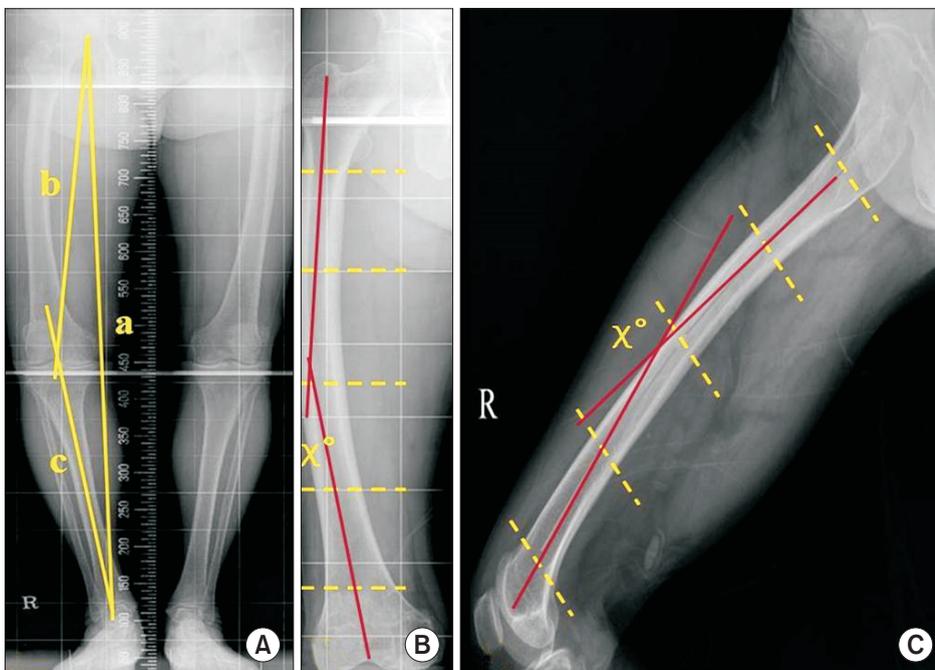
(A) Standing anteroposterior radiograph of the entire lower limbs. a: mechanical axis of the lower limb, b and c: amount of varus deformity. (B) Lateral bowing of the femur. (C) Anterior bowing of the femoral shaft.
